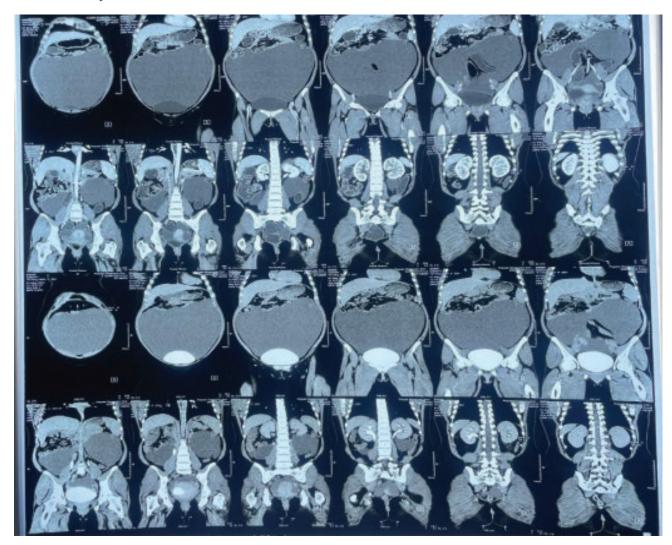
CT scan of abdomen showing giant intra-abdominal cyst displacing the bowel loops superiorly.
